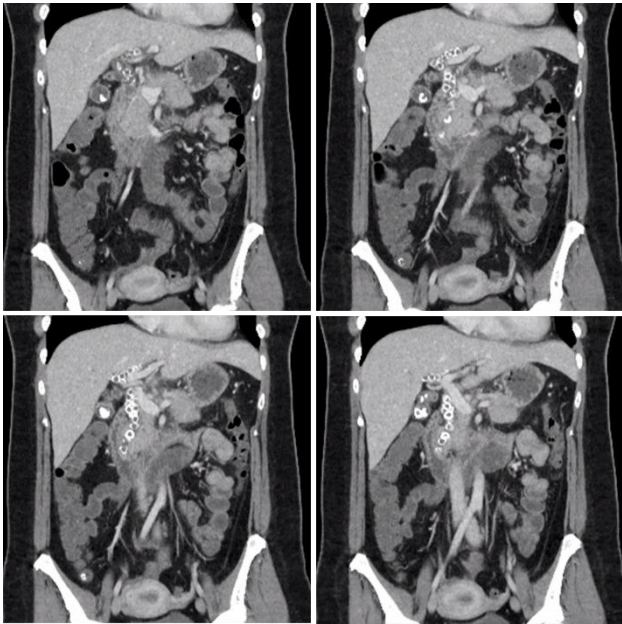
Computed tomography coronal views showing choledocholithiasis with hepatolithiasis – a string of pearls.
